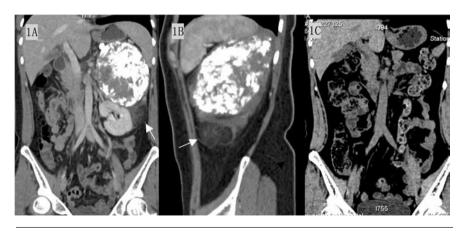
Multiple planar reconstructions showing ossified soft tissue mass as well as a lipomatous mass (arrow) adjacent to the ossified mass (A-B); computed tomography showing no recurrence at the 12-month follow-up (C).
